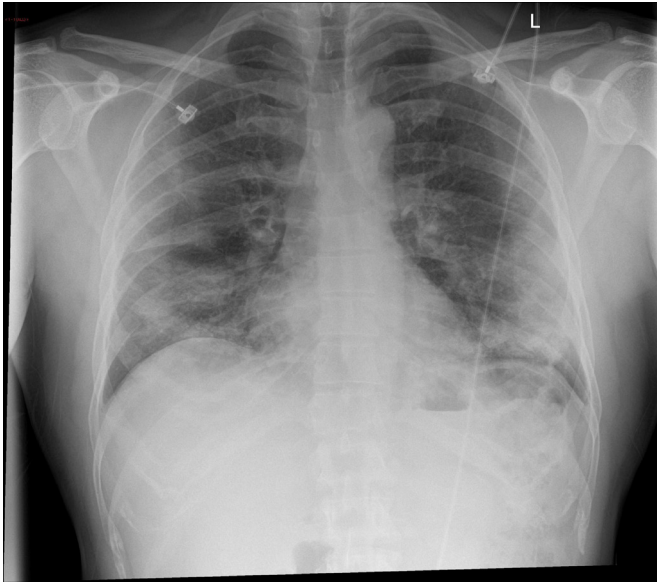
Posteroanterior chest radiograph on admission. Bilateral predominantly peripheral and basal pulmonary infiltrates in keeping with COVID-19 pneumonia.
